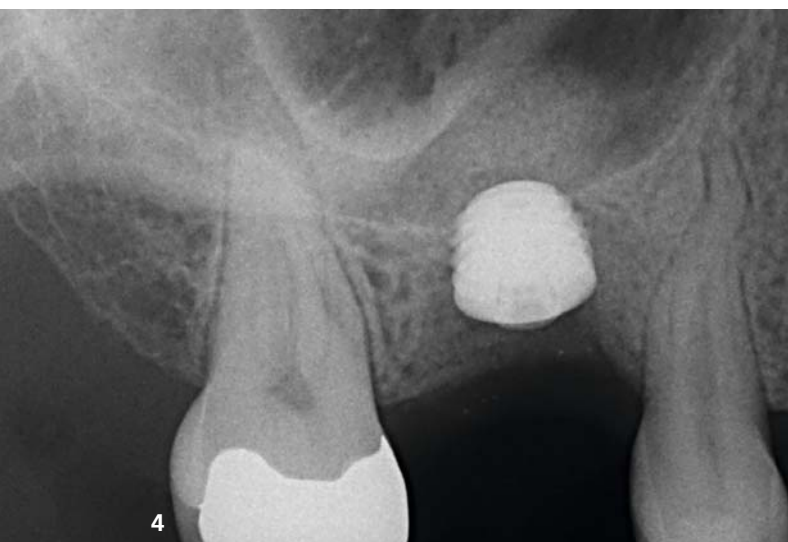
Radiographic control of the minimally invasive internal sinus floor elevation. Fig. 5: Non-irritated soft tissue two weeks after exposure. Deep implant position.
